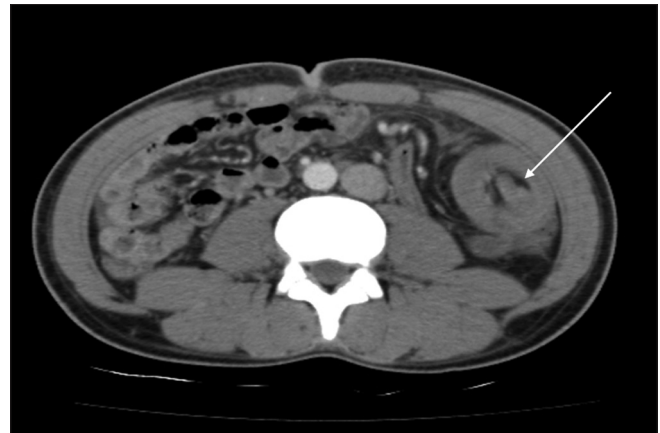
Contrast-enhanced CT scan of the abdomen demonstrated the classic findings of a target like an ileocolic intussusception, with no evidence of proximal bowel obstruction *in situs inversus totalis* (white arrow)
